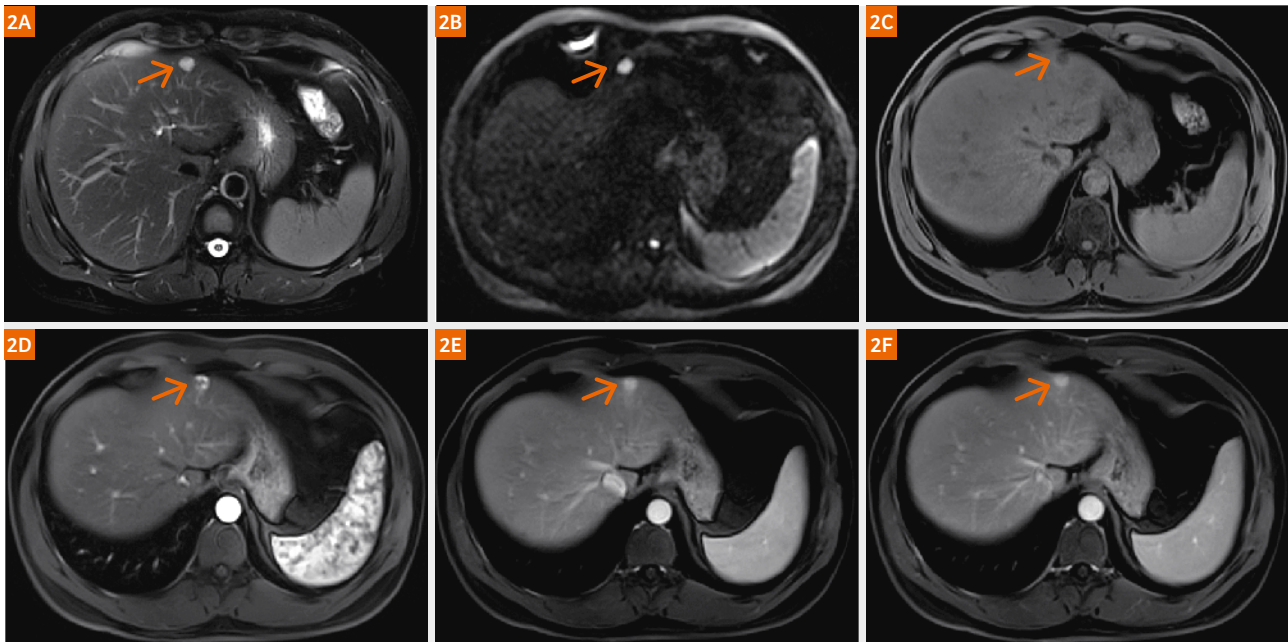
MRI images of a hemangioma: The lesion appears as a hyperintense mass on both the T2-weighted image (2A) and DWI $b = 1000 \text{ s/mm}^2$ (2B), and is hypointense on the pre-contrast T1-weighted image (2C). The post-contrast-enhanced T1w images (2D-F) show the progressive centripetal contrast enhancement in the hemangioma.
